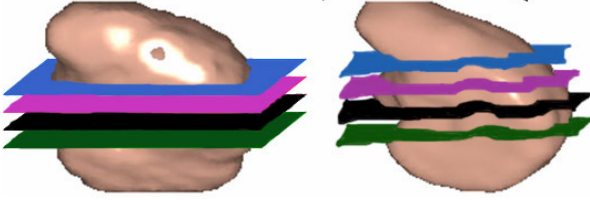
(left) Initial location of four postmortem slices within the MRI volume, and (right) the warped MRI volume matching the postmortem slices.
